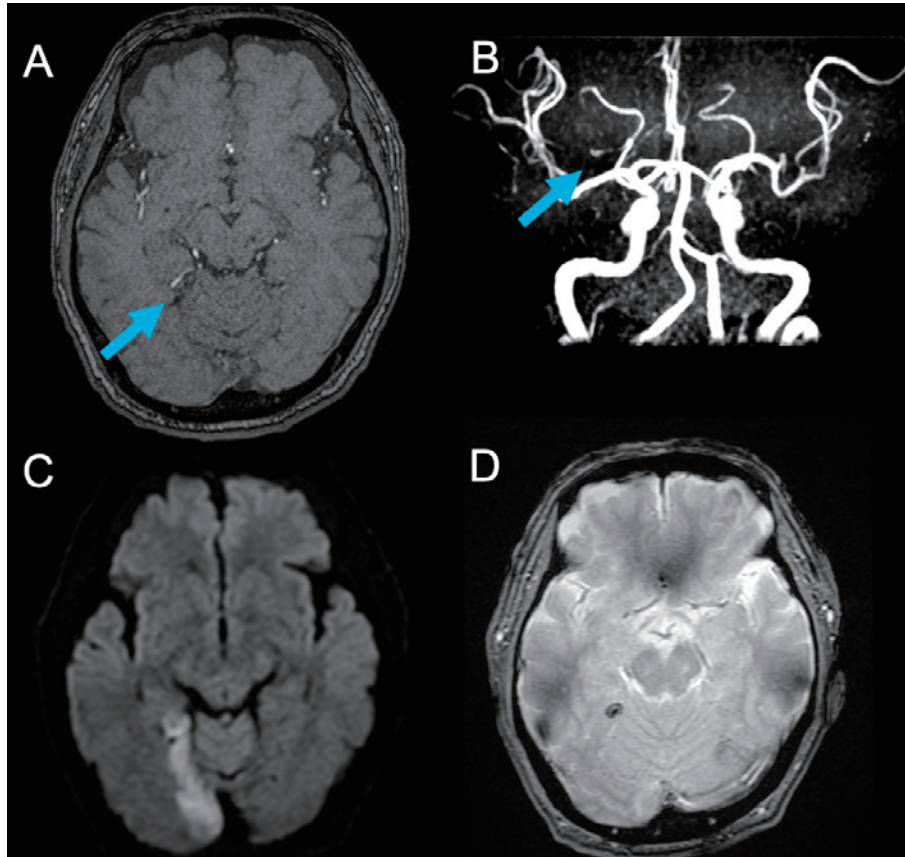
(A, B) The magnetic resonance imaging performed on day 1 (admission day) shows that the proximal part of the right calcarine artery is stenotic, and the distal part is occluded with aneurysm formation (arrow) on the upper surface of the tentorium. (C) Diffusion-weighted image shows acute infarction in the territory of the calcarine artery in the right occipital lobe. (D) T2* gradient echo shows thrombosis in the aneurysm.
